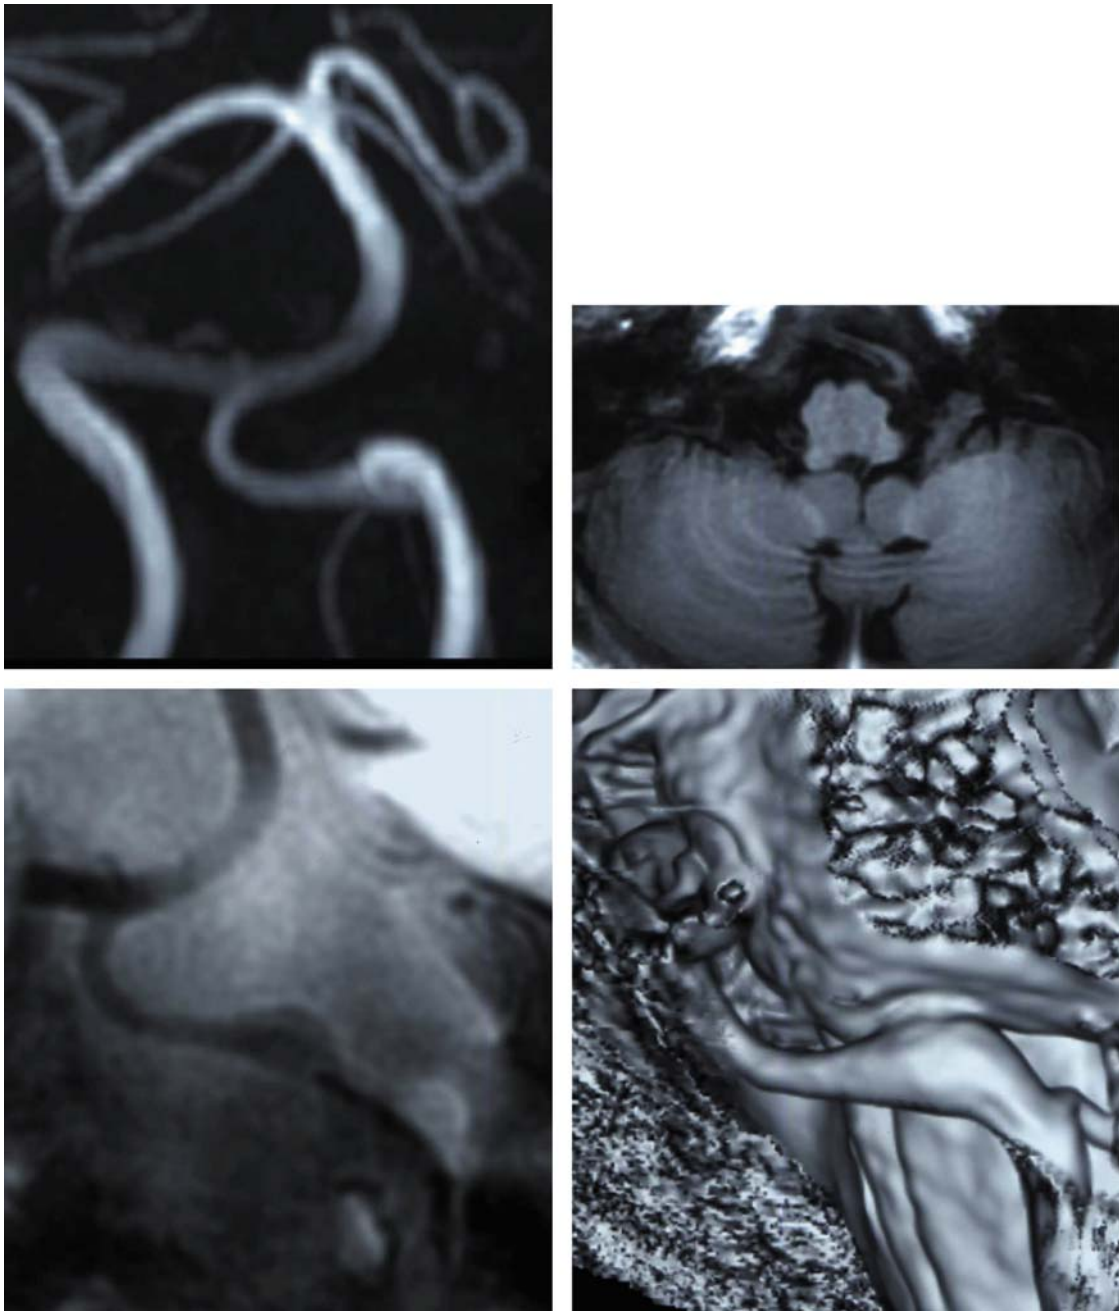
Sixty-year-old man complaining of chronic mild occipital pain. He had no history of stroke. MRA showed fusiform dilatation of the left vertebral artery (*upper left*). A high-intensity area was seen in the left vertebral wall on T1 image (*upper right*). Black blood MRI revealed a slightly high intensity area in the dilated portion of the left vertebral artery (*lower left*). 3D FIESTA MRI revealed that the surface of the left vertebral artery exhibited a sausage-like dilatation (*lower right*)
